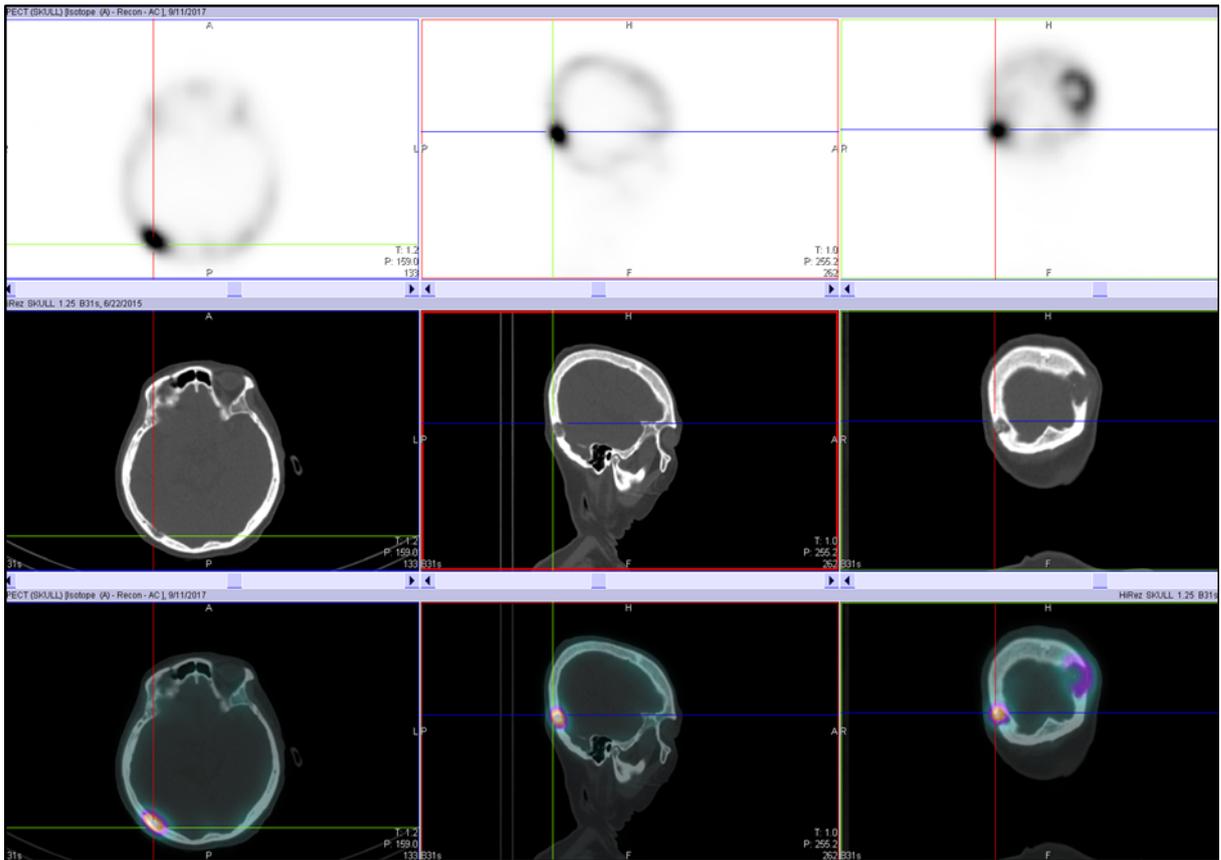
Hybrid SPECT-CT of skull (bone-window) images show abnormal increased tracer uptake at the cranium corresponding to destructive lytic bone lesions with slightly sclerotic edges.
